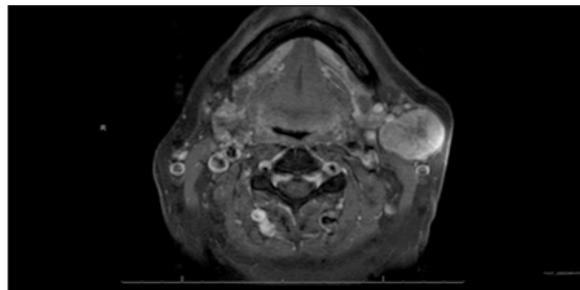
Magnetic resonance image, axial cut. Axial T1 image of tumor shows a well-defined, peripherally enhancing, 3.5-cm lobe mass.
